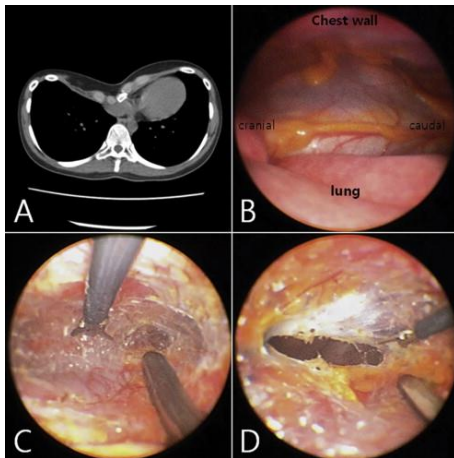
(A) Chest computed tomography showed severely depressed anterior chest wall resulting in dimensional and location changes of heart. (B) Applying Crane technique, (C) needlescope demonstrated the pectus clamp and endo scissors approaching the substernal area and (D) reaching the opposite pleura.
